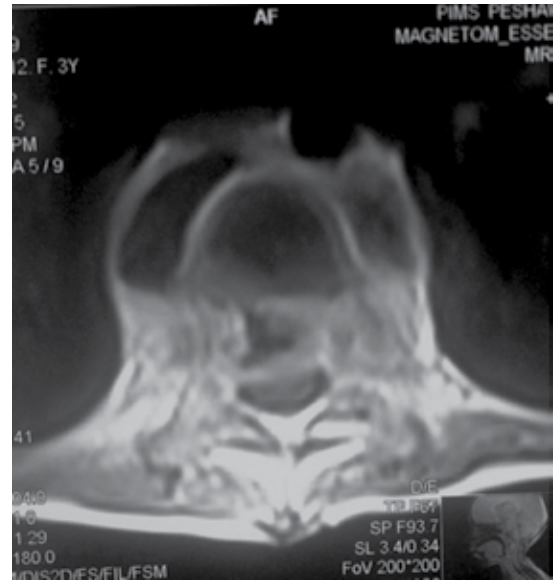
Post contrast axial MRI image of a dorsal vertebra reveals enhancement of the vertebra along with pre and para vertebral collections.
